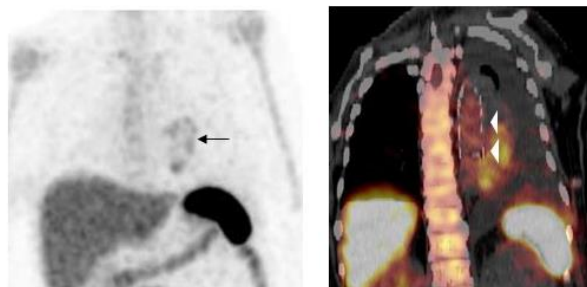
Infected aortic graft. Note the increased labeled leukocyte uptake in the left chest (arrow) on the maximum intensity projection (left). On the coronal SPECT/CT image (right), this activity is within the aortic graft (arrowheads).
